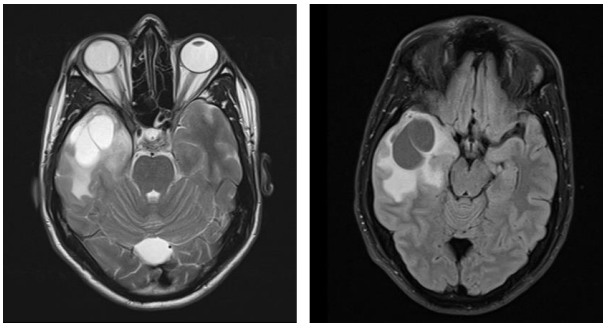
Pre and post IV contrast MRI Brain showing well defined peripherally enhancing lesion with perilesional edema in the right temporal region which is hyperintense on T2W image, suppressed on FLAIR, hypointense on T1W images with evidence of enhancing pachymeninges adjacent to the lesion.
